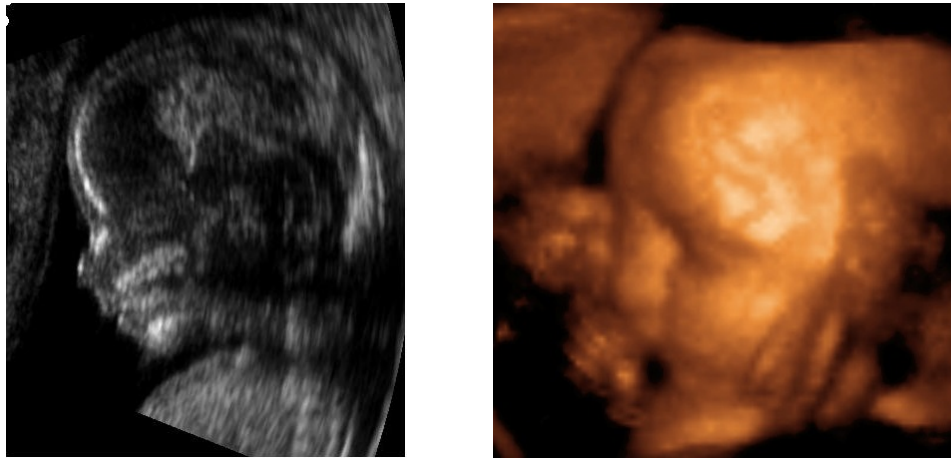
Ultrasound images of a fetus. Left conventional Ultrasound, right 3D Ultrasound.
